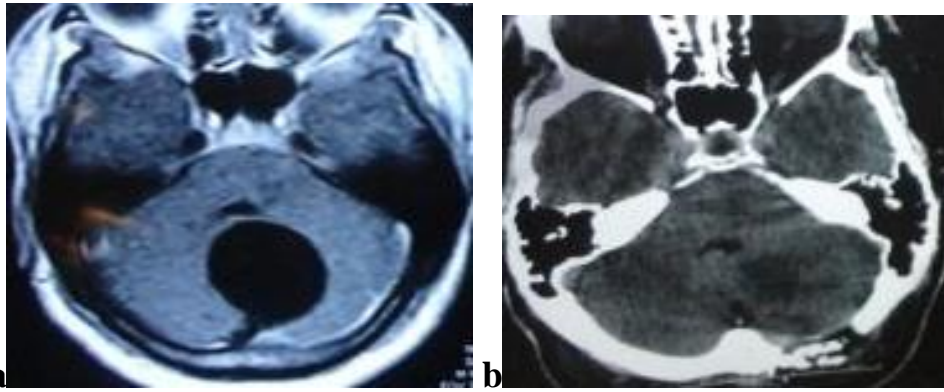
a,b): Radiological results of posterior fossa IAC total excision; a) preoperative MRI brain axial cut, and b) one week postoperative CT brain axial cut shows disappearance of the cyst.
